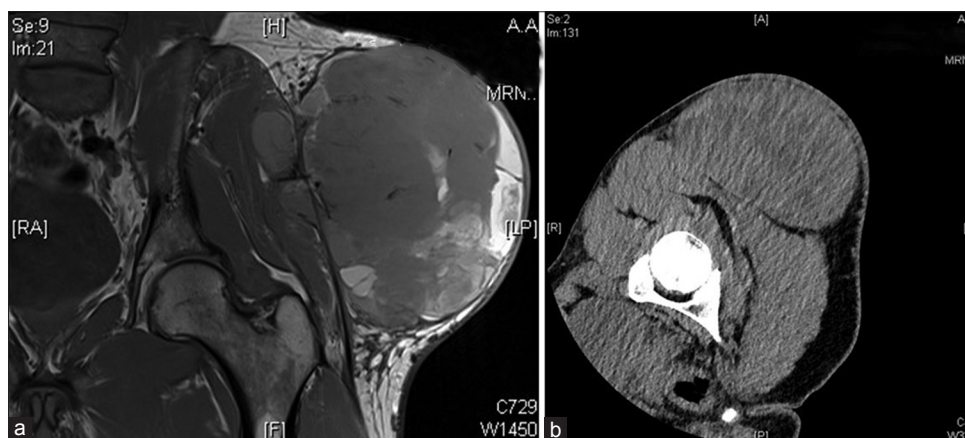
(a) Magnetic resonance imaging and (b) Computed tomography of a left gluteal synovial sarcoma. This patient successfully underwent wide resection and plastic reconstruction with a latissimus dorsi flap
